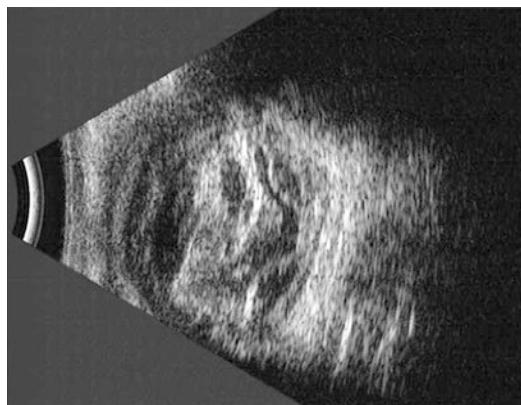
B ultrasound demonstrated severe vitreous hemorrhage and retinal detachment
